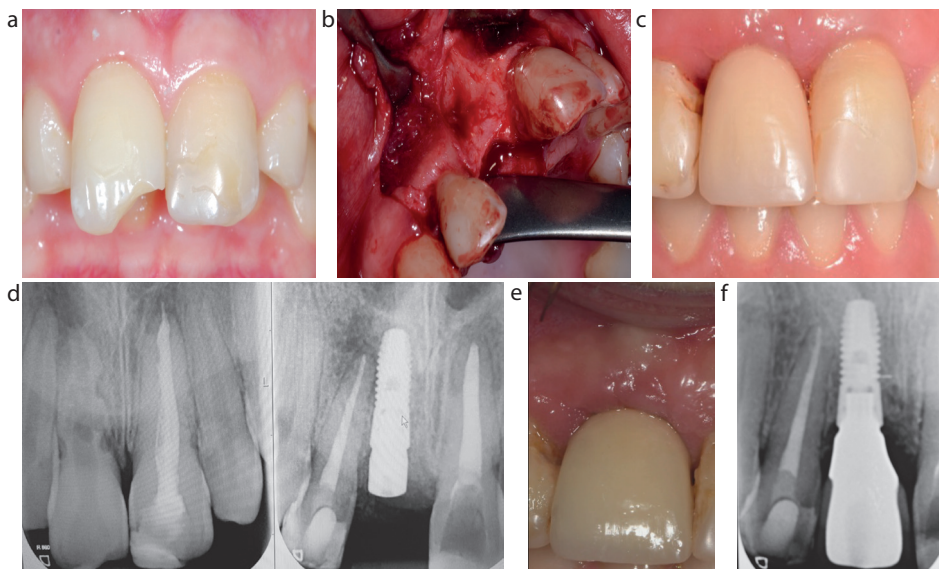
(a) Trauma case with endodontically and structurally compromised anterior teeth. (b) UR1 was extracted and replaced with single implant crown due to the severe root resorption and persistent infection. (c) Provisional implant crown replacing UR1. (d) Radiographs show compromised teeth adjacent to the UR1. UR2 was root canal treated and UL1 had Re-RCT. UR1 was replaced with an implant crown along with GBR. (e) Definitive implant crown showing stable soft and hard tissues around dental implant UR1. (f) Radiograph taken 2 years post-operatively showing no bone loss around the implant replacing UR1.
